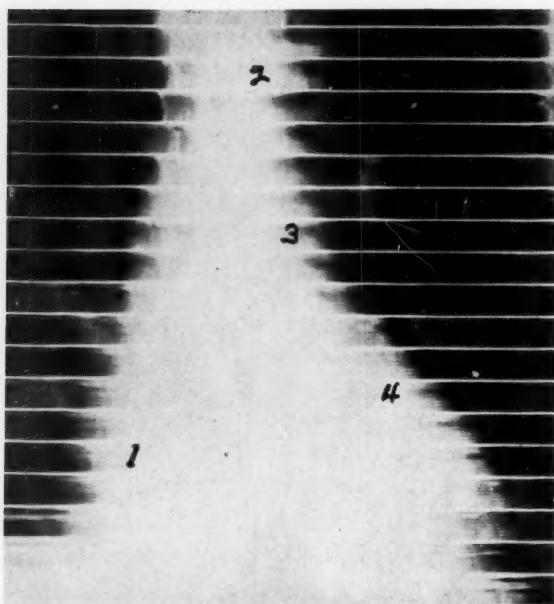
Case 1: Roentgenographic kymogram of heart in presence of popliteal fistula, which was closed by digital compression during first half of exposure and open during second half of exposure. (See Fig. 8.)
